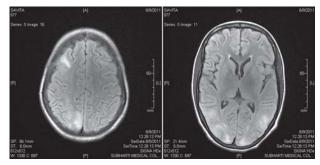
Magnetic resonance imaging of the brain showing septic emboli in the parietal and occipital regions.
